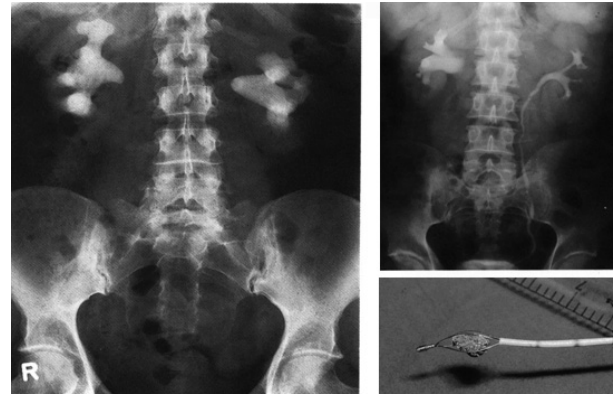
X-ray investigation shows staghorn stone (left), and Dormia basket extraction of the stone (right)
